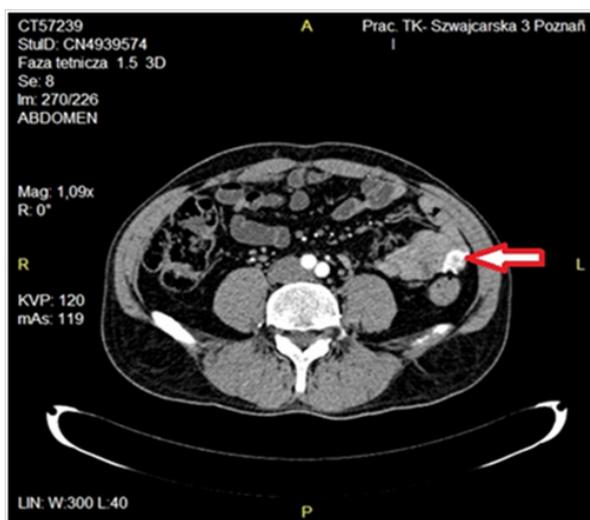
CT-enhanced scan - tumor localised in the left midgastrium originating from small intestine enhancing in arterial phase.
